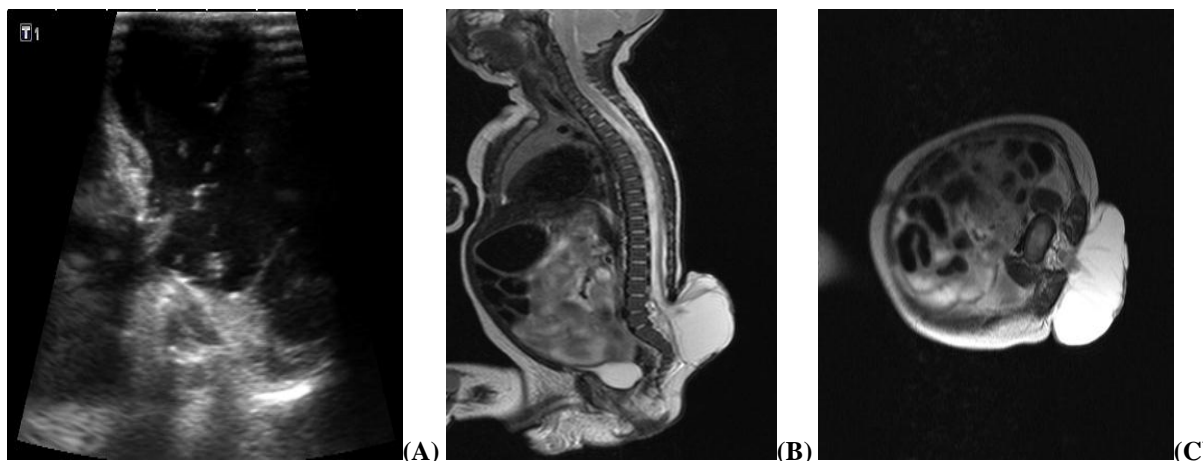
Myelomeningocele sac with neural placode and nerve roots (A) showing Ultrasonographic Images (B) Sagittal image and (C) Axial image
